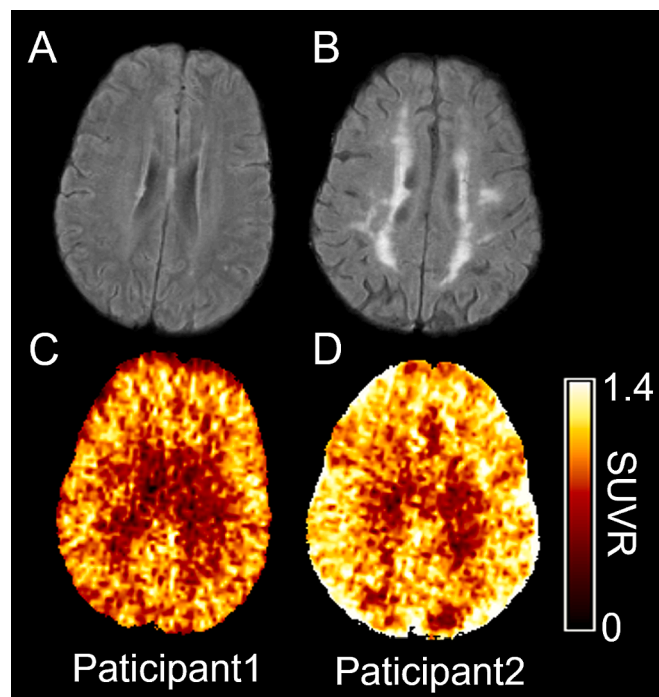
Baseline MR FLAIR images (A, B) and PET ¹¹C-PK11195 SUVR maps (C, D) from two representative participants. WMH volumes were 1.89 ml and 45.44 ml, and the whole brain ¹¹C-PK11195 SUVR were 0.94 and 1.07 in Participant 1 and Participant 2, respectively. ¹¹C-PK11195 SUVR was higher in participants with larger WMH volume.
